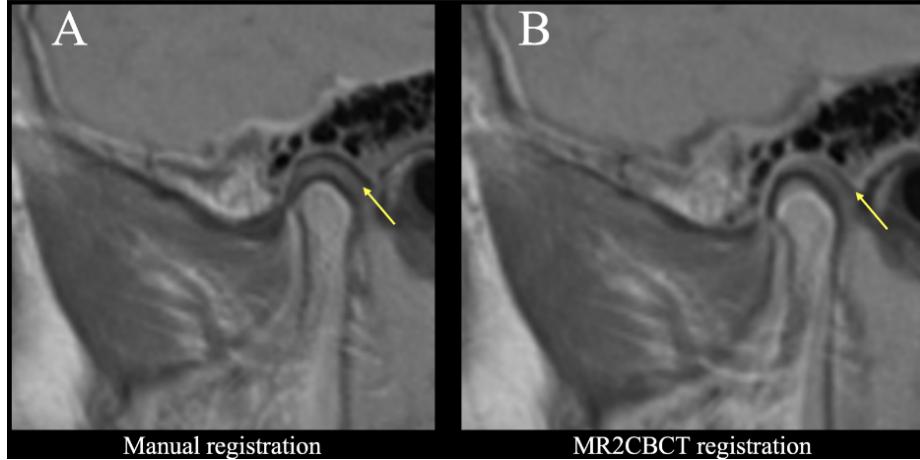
MRI-CBCT Overlays: (A) Manual registration; (B) Post MR2CBCT Registration using the Cranial Base as a stable region of reference. Note that the CBCT was taken with the mouth slightly open which may have been challenging for the clinician performing manual registration; also note how the fit of the cranial base was improved in the mutual information registration performed by the MR2CBCT algorithm in B.
